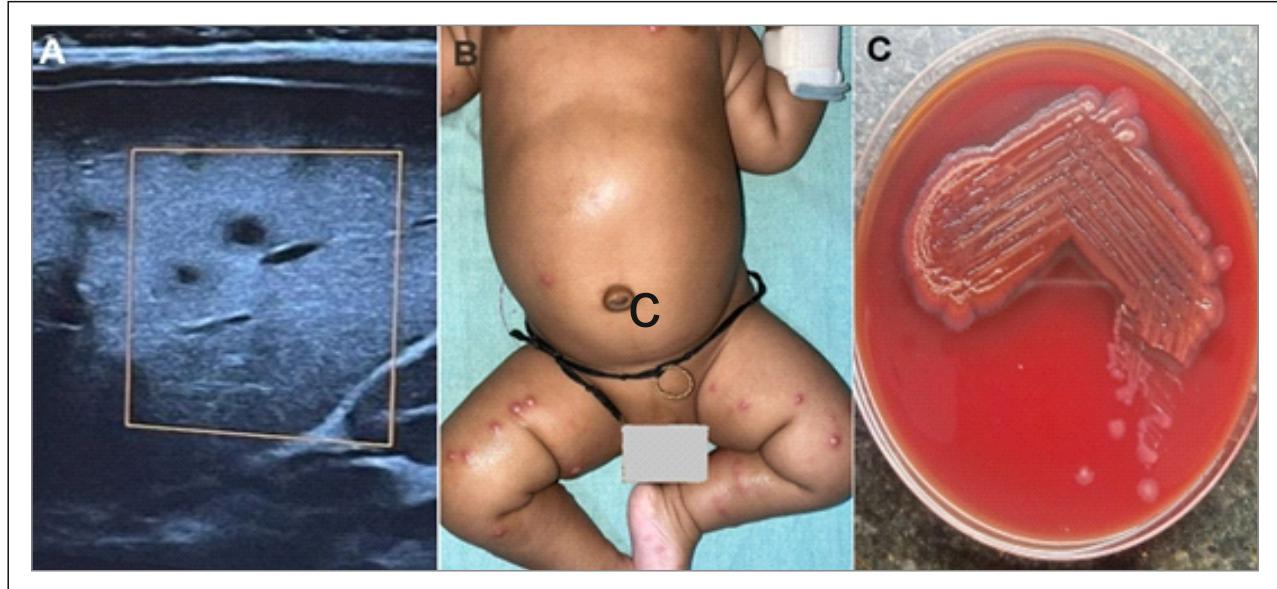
(From Left to right) A) High-resolution ultrasound of 40-day old male with persisting fever spikes showing multiple hepatic micro-abscesses B) Multiple pustular lesions over the trunk and extremities at 45 days of life C) Blood agar showing pink colored colonies of Roseomonas species.
